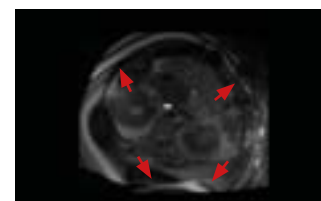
Image of MRI showing wrap around artifact (arrows) due to patient size exceeding MRI field of view.
